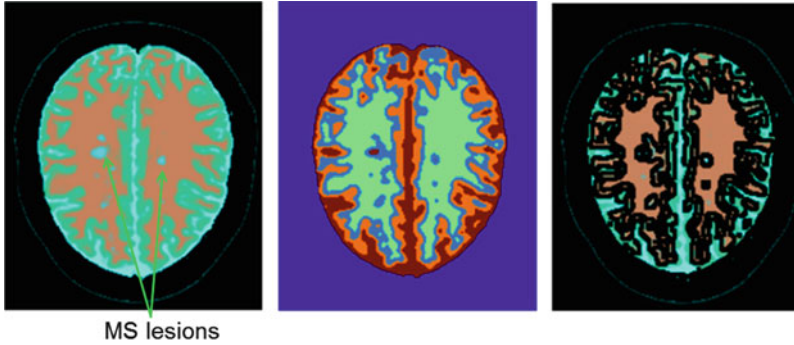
The original MRI with MS lesions after preprocessing (*left*), the false-colored cluster labels (*middle*), and the resulting segmented image (*right*) [15]
